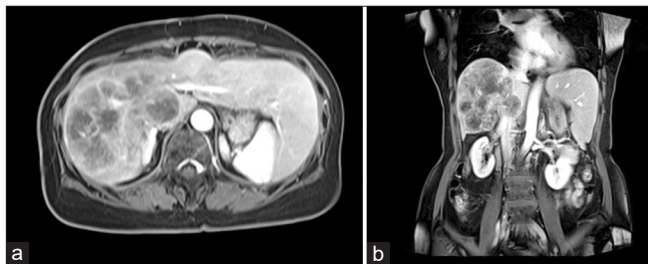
Magnetic resonance imaging revealed a large, lobulated mass in the right lobe of the liver, as shown in the axial view (a) and coronal view (b)
